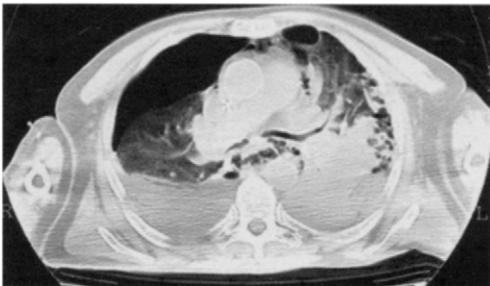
Axial CT. Pneumomediastinum with tiny lucencies especially around distal oesophagus.
